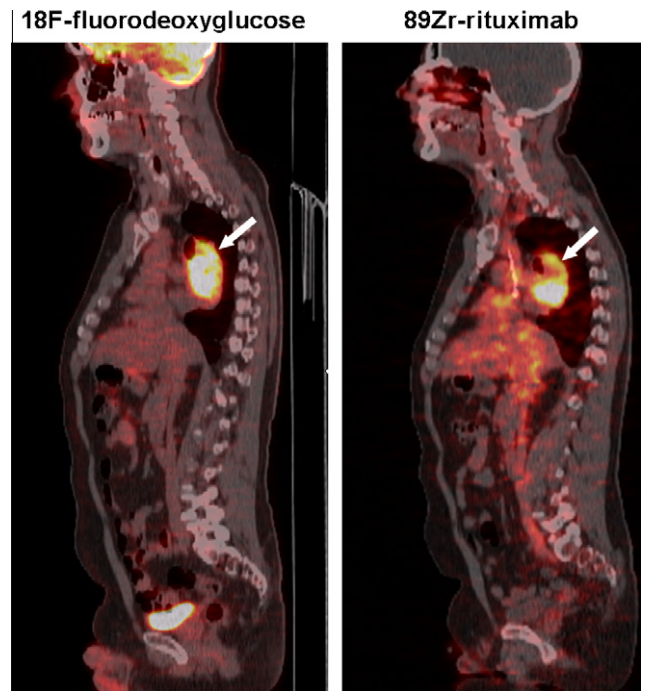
Comparison of an FDG-PET-CT scan (left) and an ^{89}Zr -rituximab PET-CT scan (right) in a patient with relapsed follicular non-Hodgkin's lymphoma. The bottom part of the tumour shows significant higher rituximab uptake than the upper part. See power point version of the figure in the Supplementary data.
